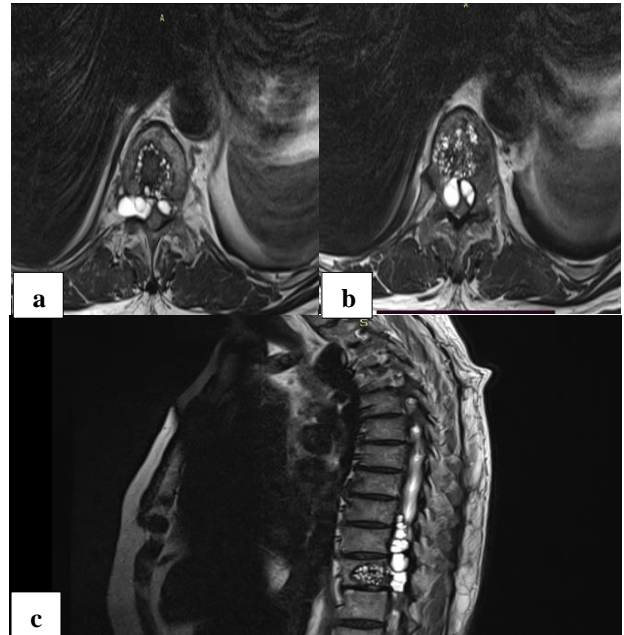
MRI images showing spinal hydatid cyst in thoracic vertebra.
